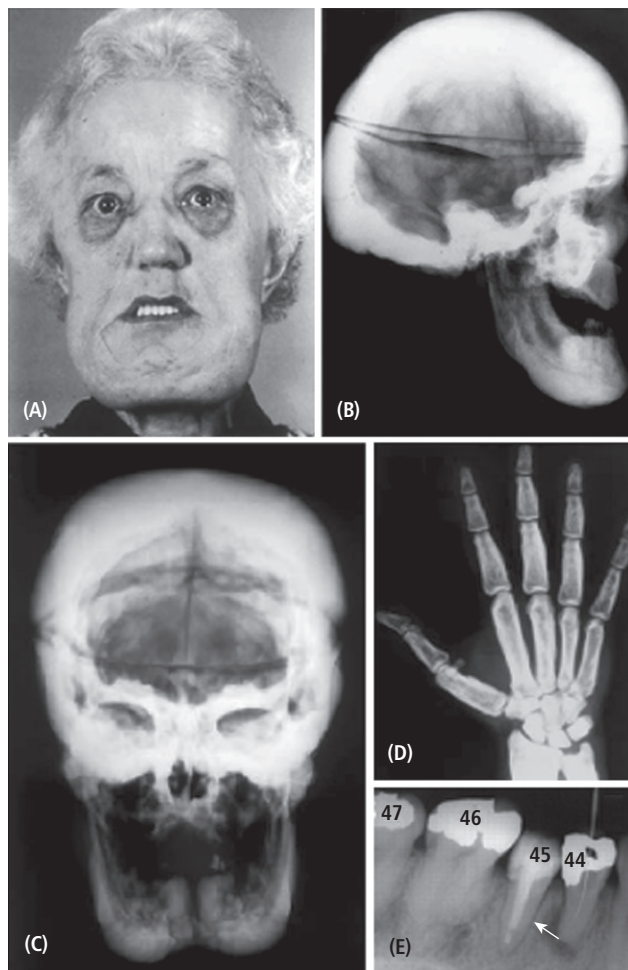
Photographs and radiographs of patients with VBD. (A) VBD patient with a protruding chin. (B–C) Anteroposterior and lateral view of a postmortem skull of a patient with VBD. Extensive sclerosis of the calvaria and skull base and enlargement of the mandible are visible. There is loss of diploë of the calvaria. (D) Radiograph of the right hand of a 52-year-old male patient, showing endosteal thickening of the diaphyseal cortices of the short tubular bones with obliteration of the medullary canal, and disturbance in modeling. (E) Radiograph of premolars (44 and 45) and molar teeth (46 and 47) of a 43-year-old female patient with VBD. The premolar (45) shows a radiolucent periodontal space not seen at the first and second molars (46 and 47). (Figure 9.3A–C is reprinted from Van Hul *et al.*, 1998, with permission from Elsevier. Figure 9.3D is reprinted from Vanhoenacker *et al.*, 2000, with permission from Springer Science+Business Media. Figure 9.3E is reprinted from Van Bezooijen *et al.*, 2009, with permission from SAGE Publications.)
